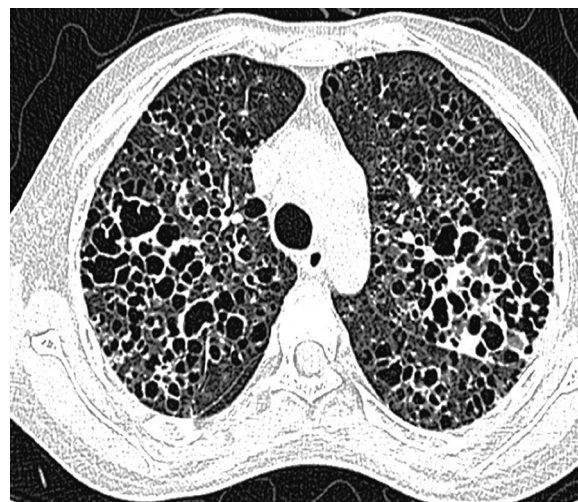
HRCT Thorax showing bilateral multiple thick walled irregular cysts.
